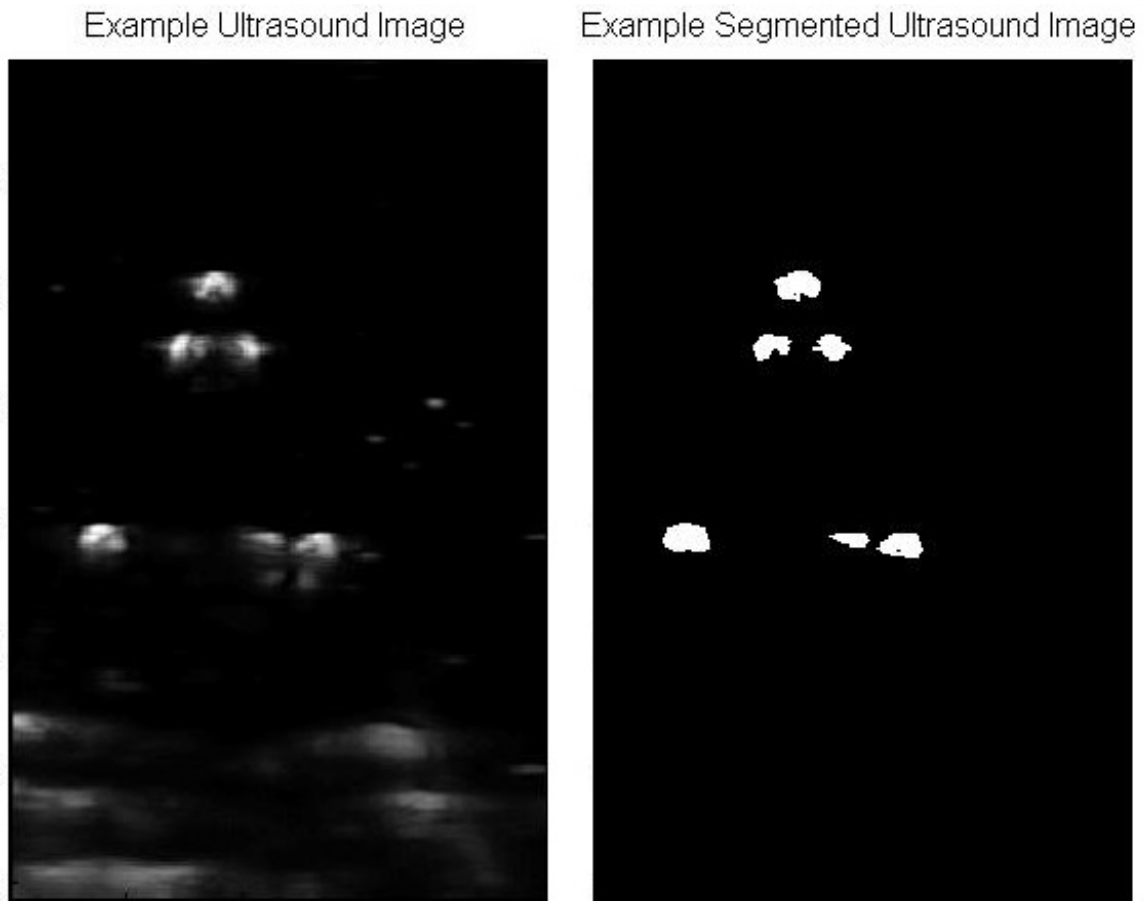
Example Ultrasound Image and Example Segmented Ultrasound Image
